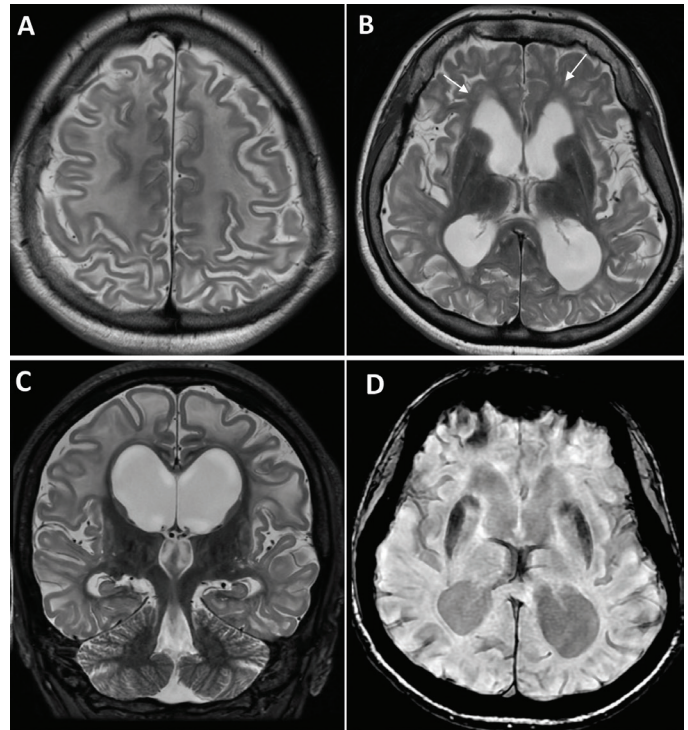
A-D) Brain magnetic resonance imaging. Axial (A, B, D) and coronal (C) sections. T2-weighted images show high signal intensity of the subcortical white matter (U-fibers) (A), with relative sparing of the periventricular white matter (B, C) and hypointense and atrophic basal ganglia. Susceptibility-weighted image (D) reveals susceptibility effects in the caudate and putamen
